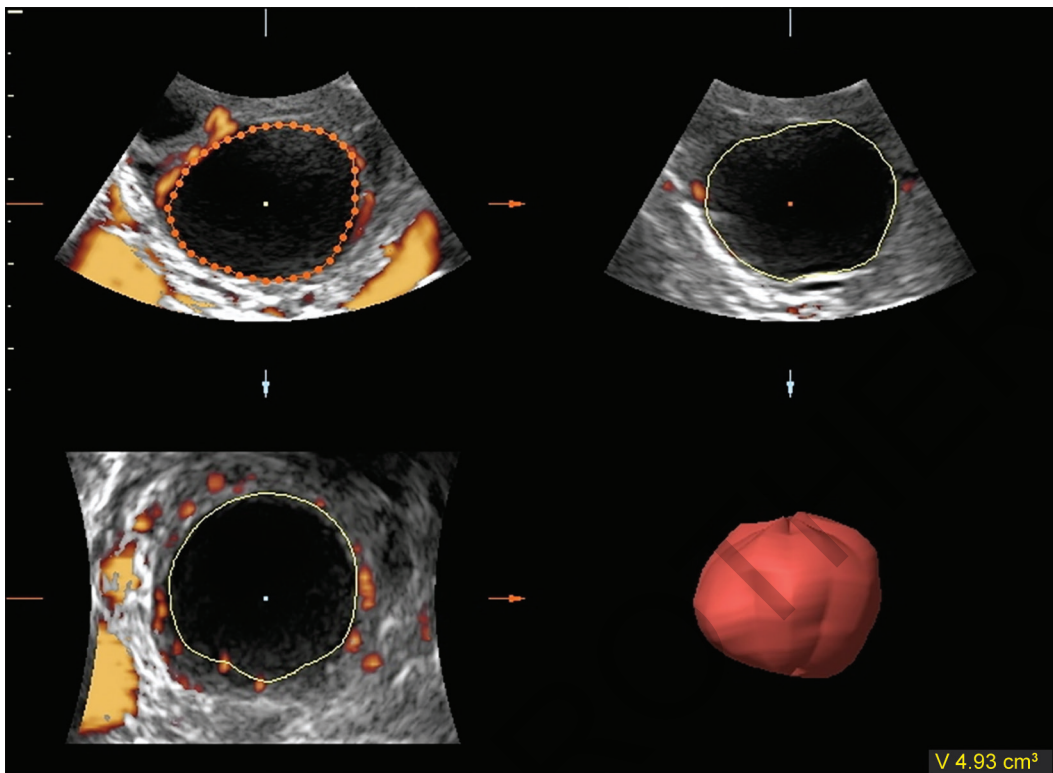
3D ultrasound acquired, virtual organ computer-aided analysis (VOCAL) calculated volume of follicle.
